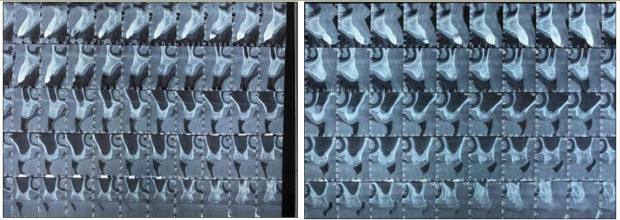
Cone beam computerized tomography
